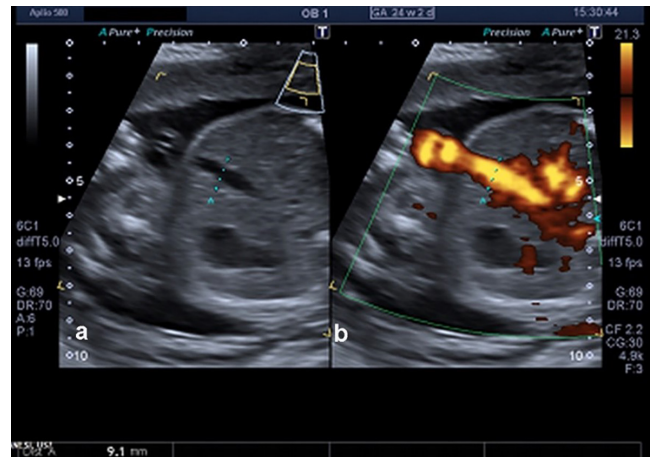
(a) Twin-view with PWD technique image of vessel diameter measurement from B mode side. (b) Twin-view with PWD technique image of vessel diameter measurement from PWD Doppler side.
